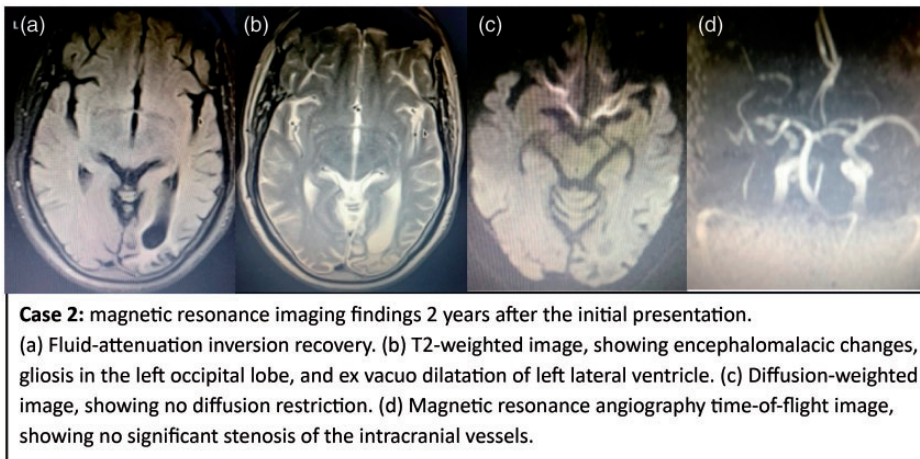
Case 2: magnetic resonance imaging findings 2 years after the initial presentation. (a) Fluid-attenuation inversion recovery. (b) T2-weighted image, showing encephalomalacic changes, gliosis in the left occipital lobe, and ex vacuo dilatation of left lateral ventricle. (c) Diffusion-weighted image, showing no diffusion restriction. (d) Magnetic resonance angiography time-of-flight image, showing no significant stenosis of the intracranial vessels.
